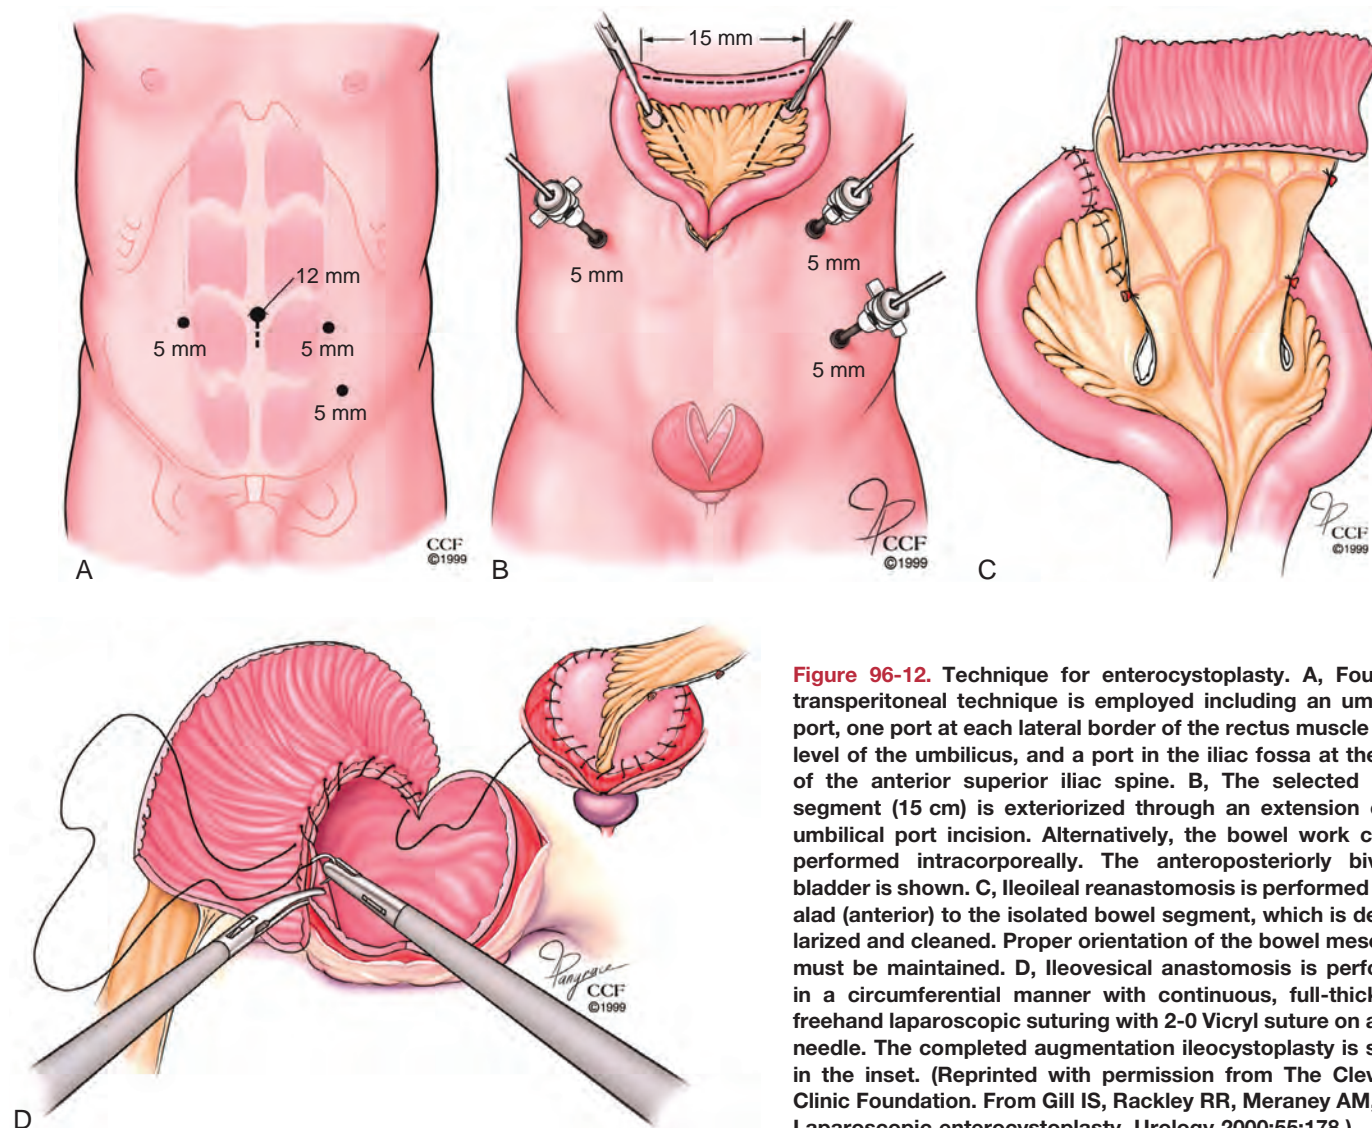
Technique for enterocystoplasty. A, Four-port transperitoneal technique is employed including an umbilical port, one port at each lateral border of the rectus muscle at the level of the umbilicus, and a port in the iliac fossa at the level of the anterior superior iliac spine. B, The selected bowel segment (15 cm) is exteriorized through an extension of the umbilical port incision. Alternatively, the bowel work can be performed intracorporeally. The anteroposteriorly bivalved bladder is shown. C, Ileoileal reanastomosis is performed cephalad (anterior) to the isolated bowel segment, which is detubularized and cleaned. Proper orientation of the bowel mesentery must be maintained. D, Ileovesical anastomosis is performed in a circumferential manner with continuous, full-thickness, freehand laparoscopic suturing with 2-0 Vicryl suture on a CT-1 needle. The completed augmentation ileocystoplasty is shown in the inset. (Reprinted with permission from The Cleveland Clinic Foundation. From Gill IS, Rackley RR, Meraney AM, et al. Laparoscopic enterocystoplasty. *Urology* 2000;55:178.)
